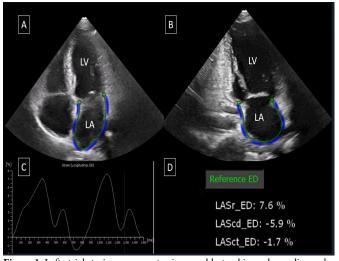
Left atrial strain assessment using speckle-tracking echocardiography (A) Apical four-chamber (A4C) and (B) apical two-chamber (A2C) views demonstrating left atrial (LA) strain analysis. The endocardial border is manually traced, and strain curves are generated. (C) Strain-time curve showing longitudinal strain measurements of the left atrium. (D) Strain values at end-diastole (ED), including LA reservoir strain (LASr\_ED), conduit strain (LASct\_ED), are displayed
